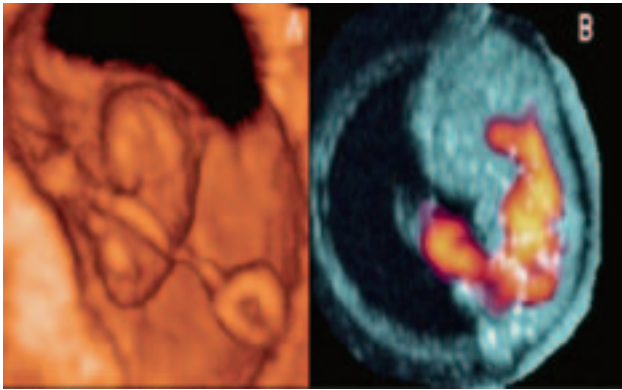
3D Power Doppler image of fetal and placental circulation.
